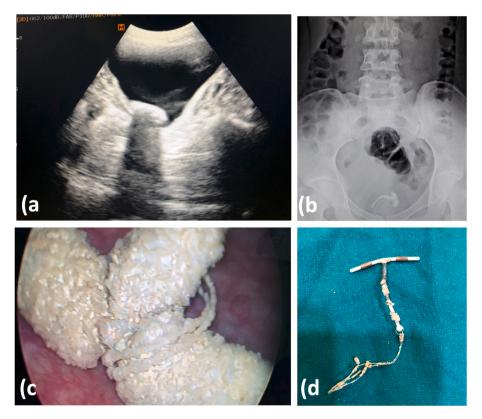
a) Ultrasonography shows large stone in the urinary bladder b) X-ray KUB shows encrusted IUD with stoneformation c) Cystoscopy showing IUD with stone formation d) Extracted IUD.
